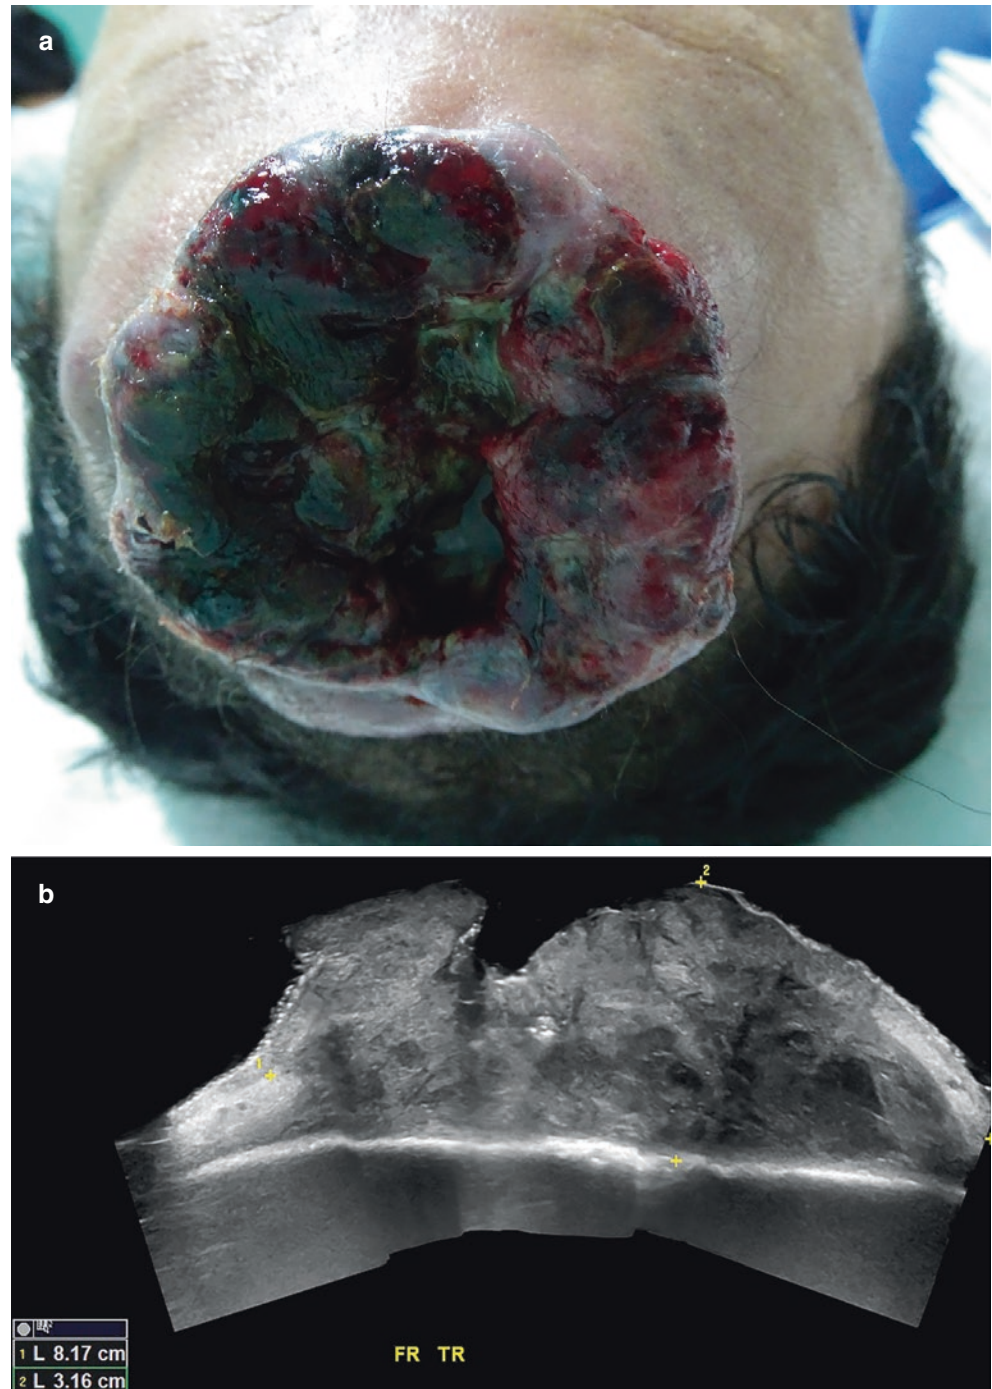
Melanoma in the scalp at an advanced stage. (a) Clinical image; (b) Greyscale panoramic ultrasound (transverse view); and (c) color Doppler ultrasound (longitudinal view) demonstrate 8.2-cm (transverse) × 3.2-cm (thickness) ill-defined, irregular, hypochoic mass that involves dermis, hypodermis, and the musculoaponeurotic layer. On color Doppler, there is increased blood flow within the lesion.
